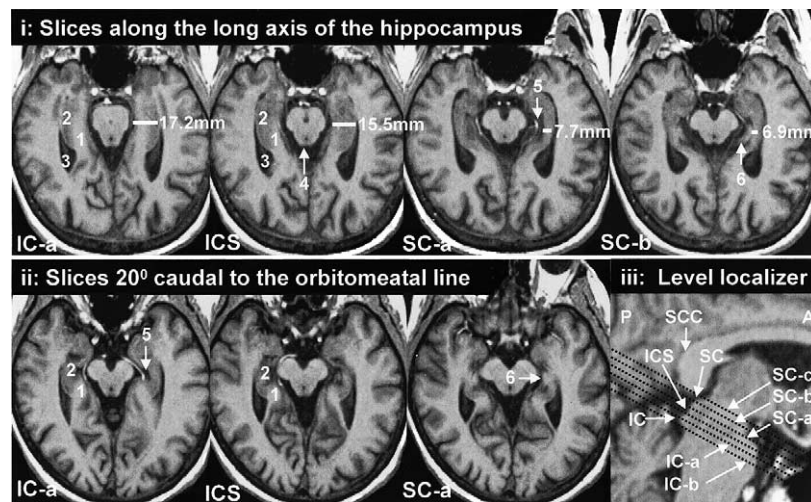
(i) Axial view of the MTL structures along the LAH at the IC-a, ICS, SC-a and SC-b levels shown in Fig. 2iii. Level localizer (A: anterior, P: posterior). IC-a shows the parahippocampal gyrus (1) and hippocampus (2) lateral to the midbrain. Note that the lateral border of the MTL is not well demarcated by the temporal horn of the lateral ventricle (3). ICS shows that the parahippocampal gyrus (1) and hippocampus (2) in the MTL region are now demarcated clearly by the temporal horn. A straight posterior border of the midbrain indicates the level of the ICS in the axial view (4). At the SC-a level, the lateral transverse fissure emerges (5), and at the SC-b level, a structure outside the MTL, the inferior thalamus (6) becomes apparent (also see Fig. 3b). The tMTL width was measured at each level and is represented by the white horizontal lines along with the width in millimeters. (ii) Demonstration of the effect of angulation on the appearance of the MTL structures in the axial MRI. Slices were oriented at  $20^\circ$  caudal to the OML from the same subject. The hippocampus (2) and parahippocampal gyrus (1) are seen as short segments and the lateral transverse fissure (5) is only half as long as the lateral transverse fissure in the images in the upper row-oriented along hippocampal axis. Number 6 indicates the inferior thalamus. (iii) Level localizer. A MR sagittal view (A: anterior, P: posterior) shows the lines through the inferior and superior colliculi depicted on axial view in Fig. 2i. AC–PC aligned MR images were reconstructed along the LAH from the inferior border of inferior colliculus (IC) to the superior border of superior colliculus (SC). Six slices (1.8 mm thick) were obtained from IC-b (the most inferior line) to SC-c (the most superior line). SCC: splenium of the corpus callosum.
